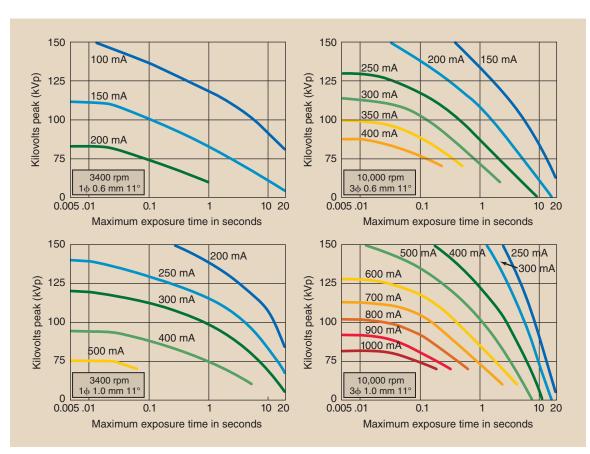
Representative radiographic rating charts for a given x-ray tube. Each chart specifies the conditions of operation under which it applies. (Courtesy GE Healthcare.)
